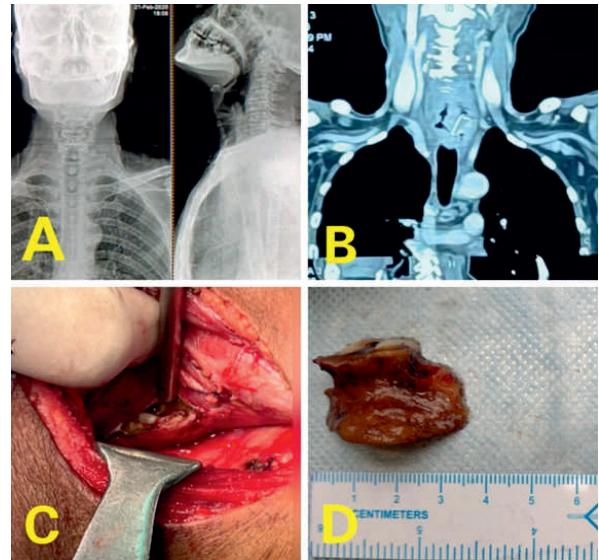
X-ray Neck anteroposterior and lateral view, B: CECT Neck showing foreign body oesophagus at level of C7-D1 vertebra, C: Denture visualised via lateral cervical esophagotomy approach, D: Artificial denture after removal from the oesophagus.
